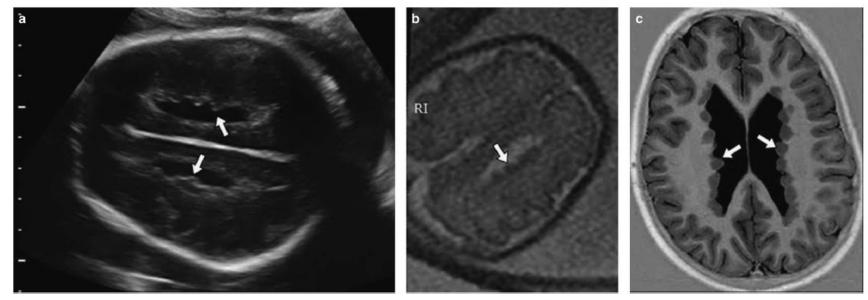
Periventricular nodular heterotopia, prenatal and postnatal imaging. (A) Ultrasound axial image at 32 gestational weeks. (B) MRI of the same fetus at 33 weeks. Note nodular bulging into the ventricles (arrows). (C) Adult MRI (axial image) showing classical periventricular nodular heterotopia (arrows) with a "string of pearls" appearance.
